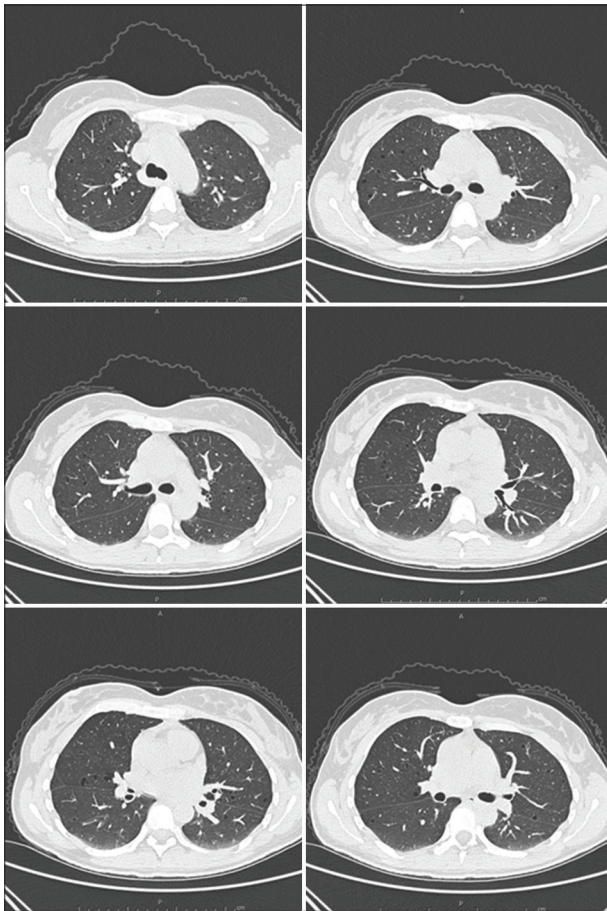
Thorax high-resolution computed tomography of case 1. Her chest high-resolution computed tomography scan was showing bilateral diffuse cysts with pulmonary nodules especially in upper and middle zones which was consistent with Langerhans cell Histiocytosis
